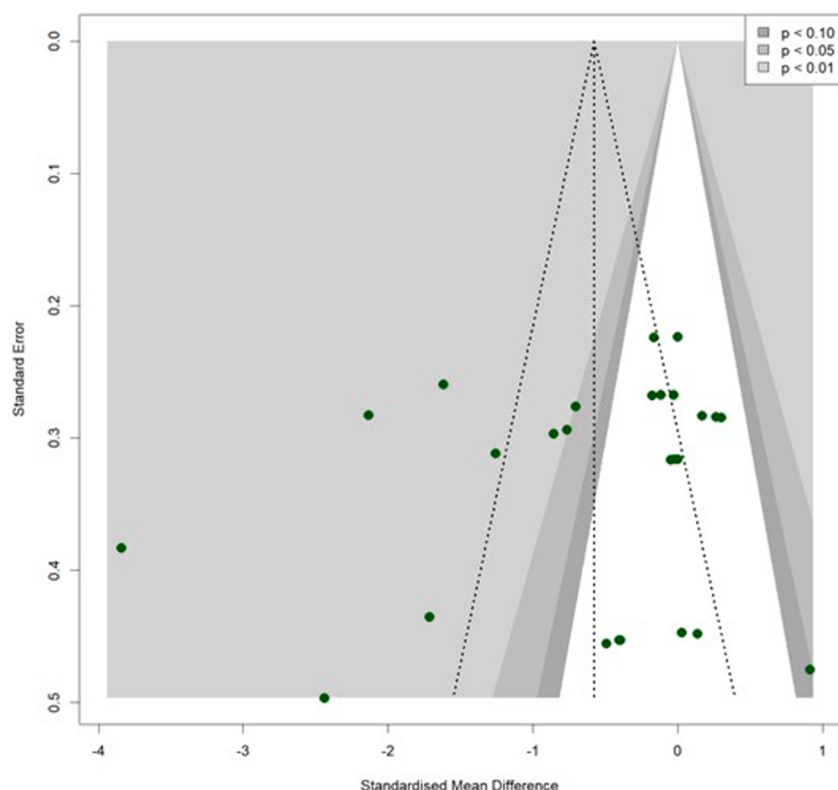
Funnel plot of standard error versus standardized mean difference for all LAI versus UAI comparisons. LAI, laser-activated irrigation; UAI, ultrasonically activated irrigation.
